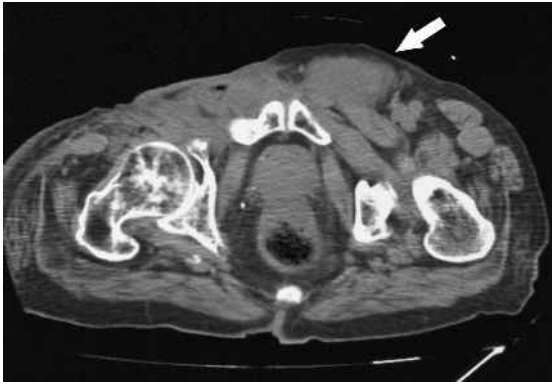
Non-contrast CT image, performed ten months after resection of the recurrent tumour in the right inguinal region, shows a recurrent tumour in the left inguinal region (arrow).
